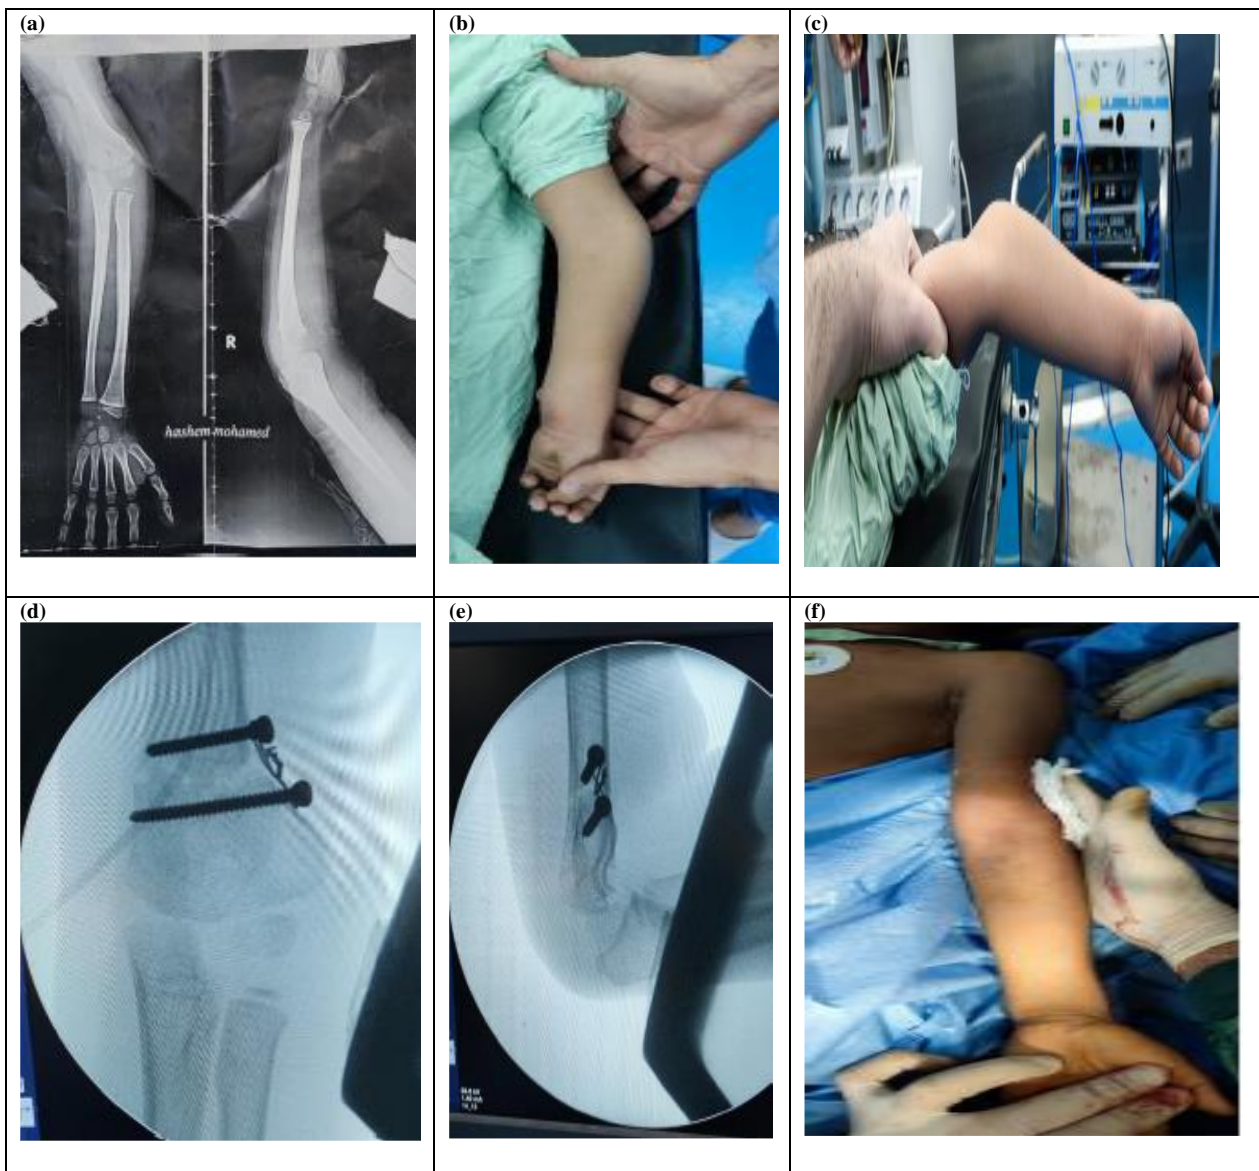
Male aged 8.5 years. The complaint was limitation of flexion (a-c) showing varus and hyper-extension; (d-f) Post-operative X-ray showing varus correction
